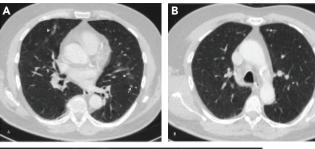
A 55-year-old male patient who has been followed-up for 3 mm and 5 mm nodules underwent computed tomography (CT) imaging for 22th month control. Non-contrast CT image shows (A) 5 mm and (B) 3 mm new appearing nodules (arrows) in the left upper lobe. Note that there is focal ground glass infiltration (arrowhead) in both upper lobes. (C) Right upper lobe image shows centrilobular nodules, which were absent in previous CT. Unless we lost contact with patient, these secondary findings may be suggestive of an infectious origin of these two nodules
